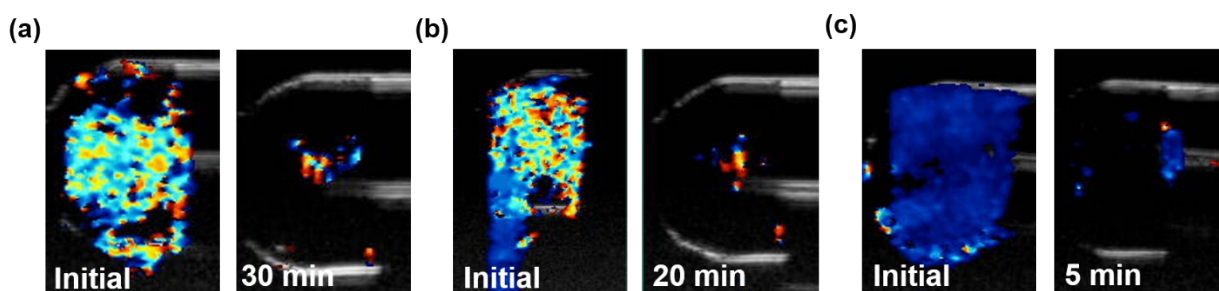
Color Doppler signal detected at (a) 0 min and 30 min for PDA-41-F, (b) 0 min and 20 min for PDA-242-F, and (c) 0 min and 5 min for commercial Definity contrast agents at MI=1.9.
